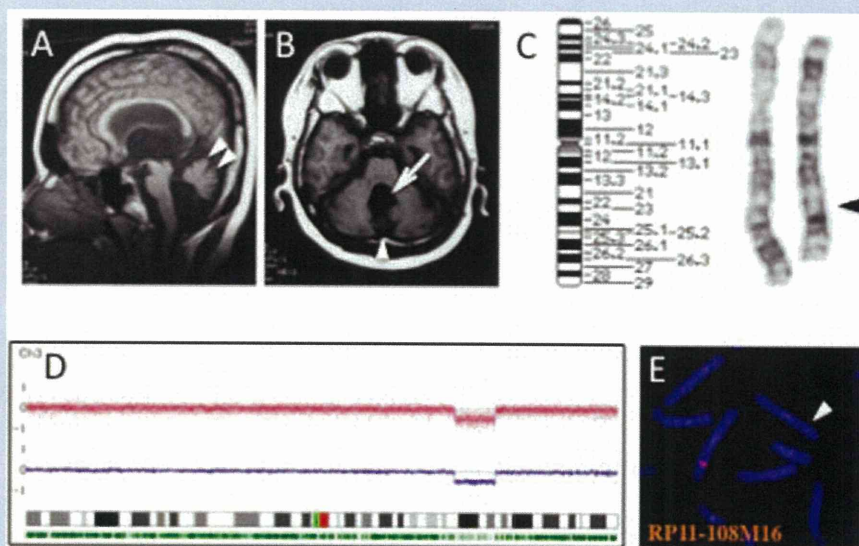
A: Brain magnetic resonance imaging of the patient. Midline sagittal T1-weighted image shows hypoplasia and upward rotation of the cerebellar vermis (white arrowheads). B: Brain magnetic resonance imaging of the patient. Transverse T1-weighted image shows hypoplasia of the cerebellar hemisphere and vermis, and enlarged the fourth ventricle (white arrow). The fourth ventricle communicates with the posterior fossa fluid space (white arrowhead). C: Partial karyotype of the patient:  $\text{del}(3)(q23q25.1)$ . The arrowhead indicates deletion. D: SNP chip analysis. A 14-Mb deletion is clearly demonstrated using CNAG 2.0 software. E: FISH analysis. RP11-108M16 covering *ZIC1* and *ZIC4* shows a heterozygous deletion (white arrowhead).
